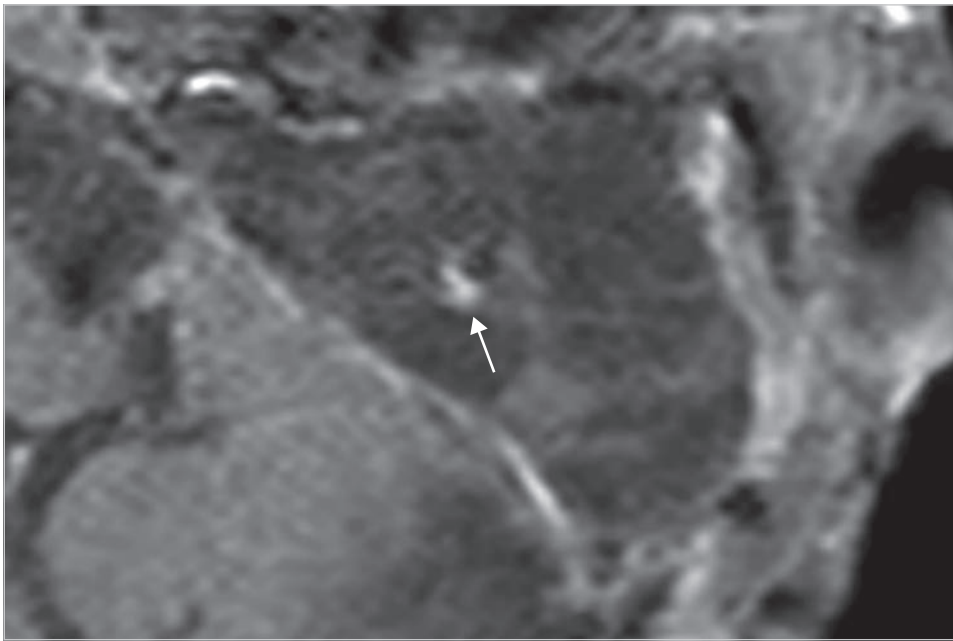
Postoperative MRI 1 week after the surgery is shown. An enhancement of the facial nerve is seen (arrow) in the abdominal fat even though the facial nerve function of the patient remained H-B grade I.
